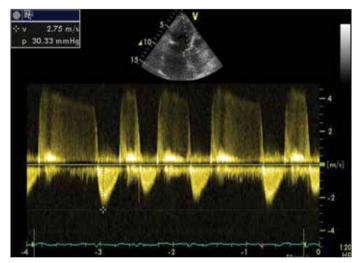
Transmembrane gradient in apical five-chamber transthoracic echocardiography view
